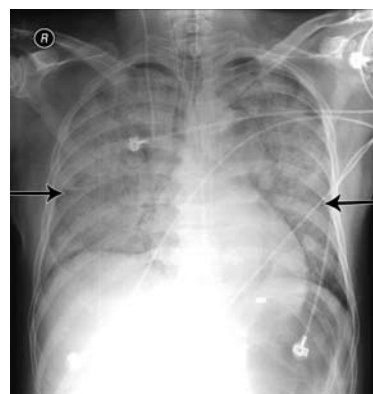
Chest x-ray showing further worsening of nodular opacities with diffuse bilateral alveolar infiltrates. The patient is intubated, and has a right internal jugular central line (arrows).
